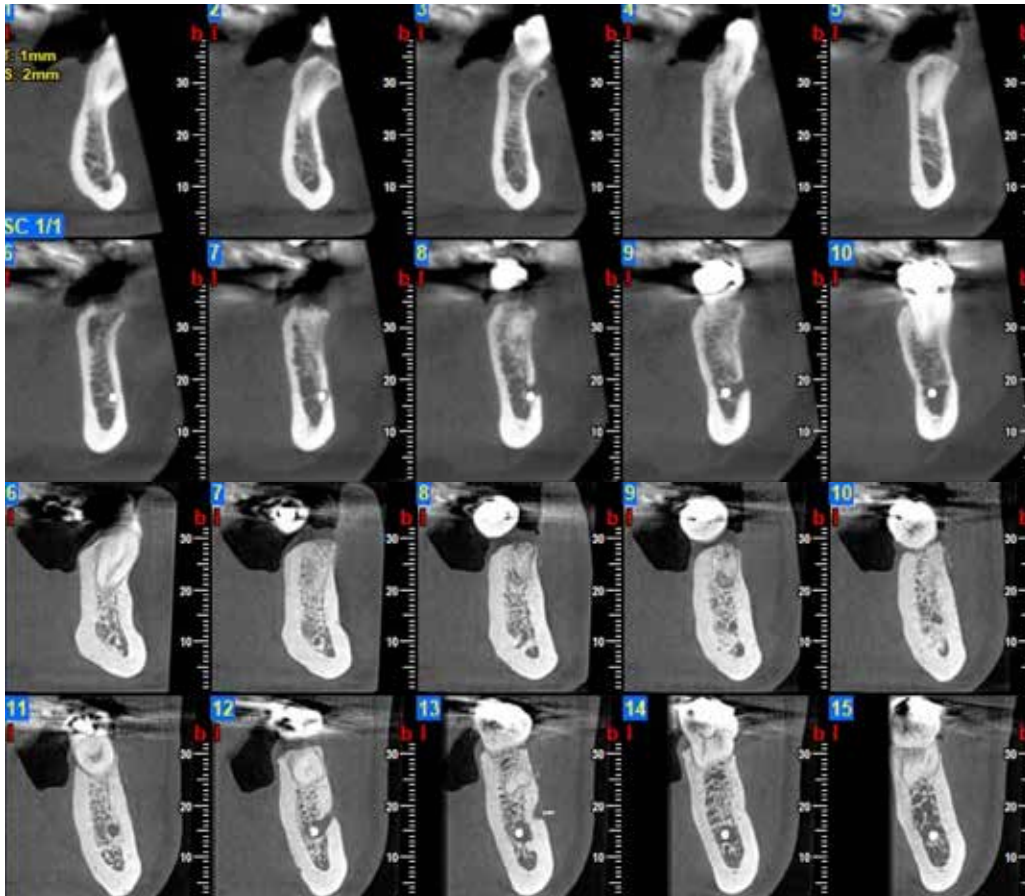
CBCT of the case taken 3 months after extraction.
